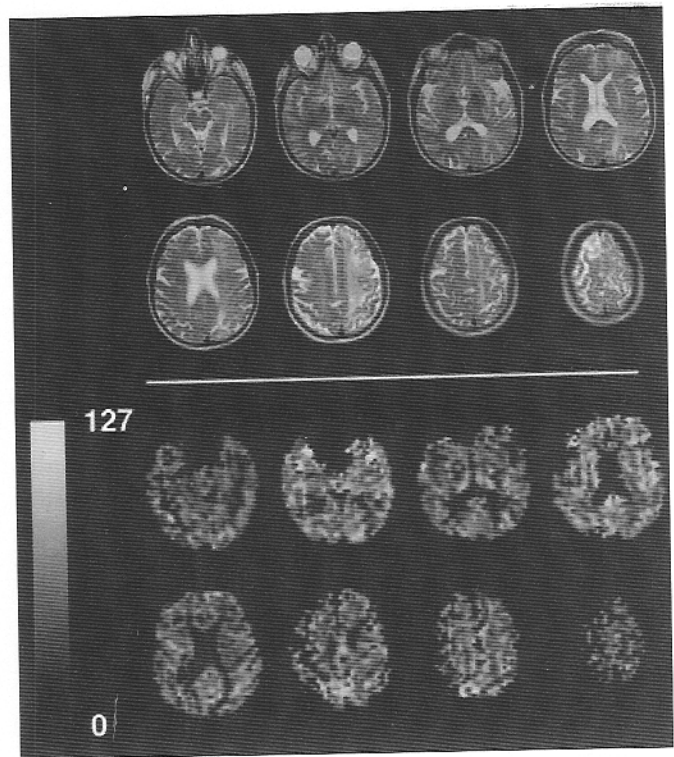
Cerebral blood flow (CBF) images and T2-weighted images from Patient 7. (Top) T2-weighted images show widespread signal hyperintensities throughout the white matter on the left. (Bottom) CBF images do not reveal any corresponding hemispheric changes, and CBF values are in a normal range. Grayscale shows CBF ranging from 0 to 127 mL/100 g/min.
